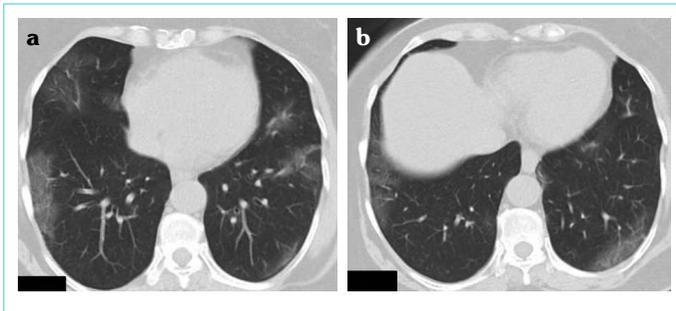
58-year-old woman with a positive RT-PCR. Axial unenhanced thorax CT images (a, b) in parenchyma window show bilateral, multifocal and peripheral ground glass-opacities
